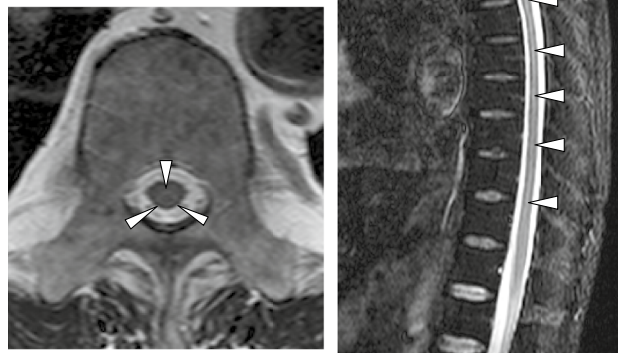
Spinal magnetic resonance imaging of case 3. High signal intensity was detected on short TI inversion recovery (STIR) images around the central canal at spinal cord positions coinciding with the dermatomes where pain was experienced
